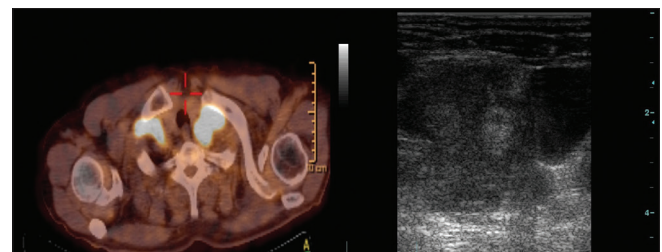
Hypermetabolic lesion in the region compatible with the left supraclavicular lymphoid gland on positron emission tomography-computed tomography. Ultrasonographically in approximate dimensions of 3 cm × 3 cm, irregular margin hypoechoic lesion
